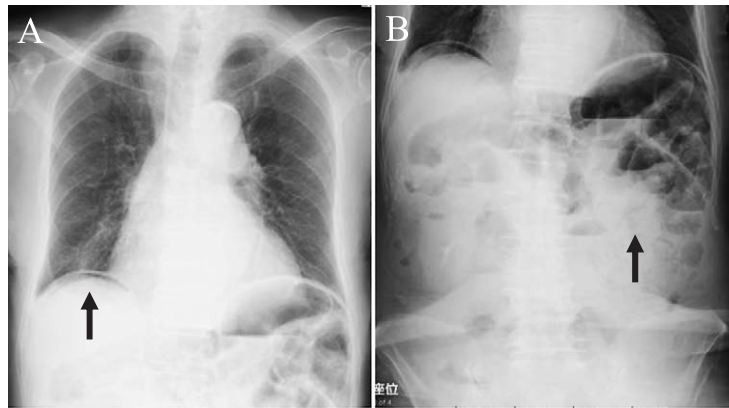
Abdominal radiography on the day of admission
